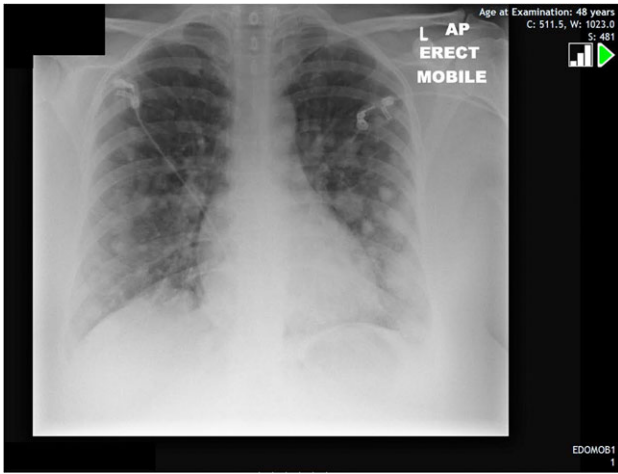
Chest X-ray displaying multiple widespread pulmonary nodules.
